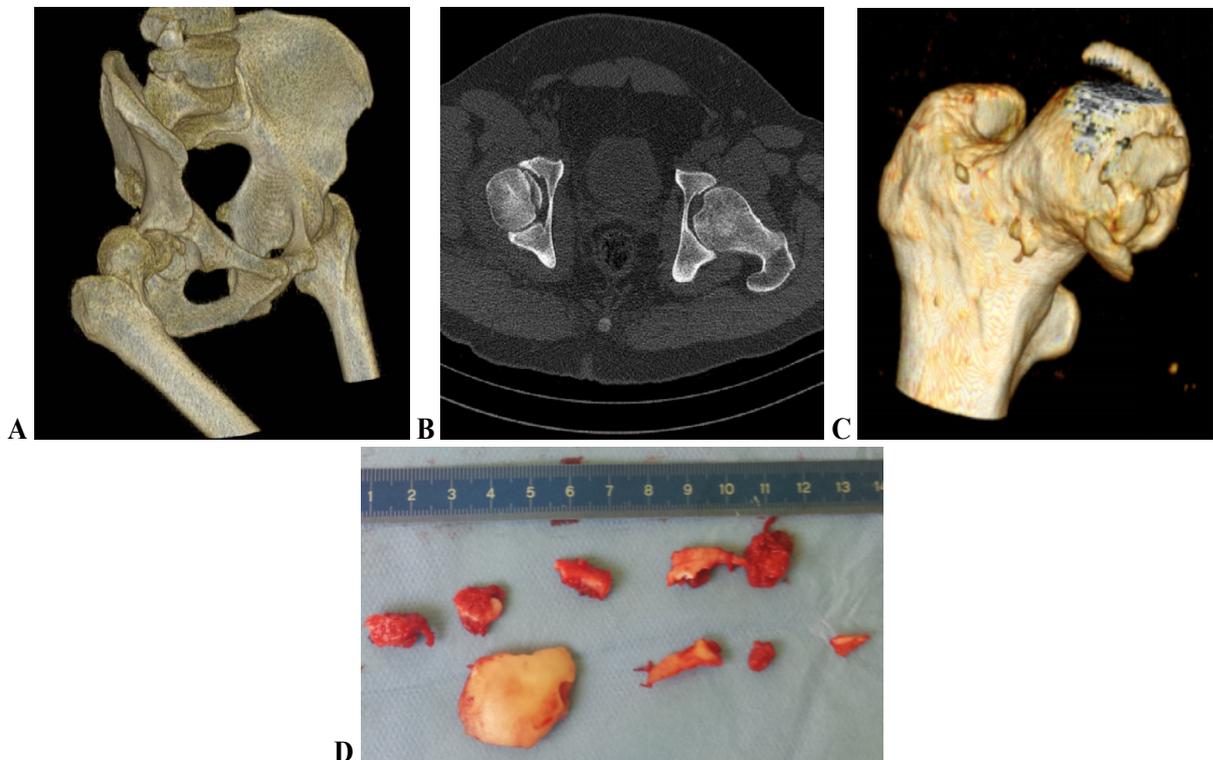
31 years old male patient treated surgical. The initial 3D CT showed postero-superior dislocation of the hip associated with a femoral head fracture inferior to fovea centralis (A). After reduction we observed on CT a non-anatomical reduction of the fracture (B, C) that required surgery - excision of intra-articular free bodies (D).
